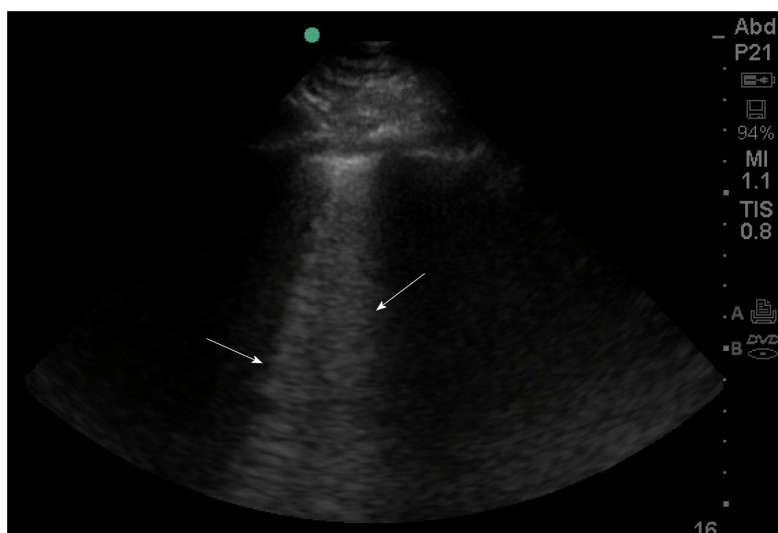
B-lines on lung ultrasound. Phased array probe (1-5 MHz) with probe marker facing cephalad placed in an intercostal space. B lines (denoted by arrows), are well-defined comet-tail, vertical hyperechoic artifacts arising from the pleural line that obliterate normal A-lines, and descend to the bottom of the screen. Multiple B-lines in an interspace indicates an interstitial syndrome, where there are increased air-fluid interfaces creating this artifact.
